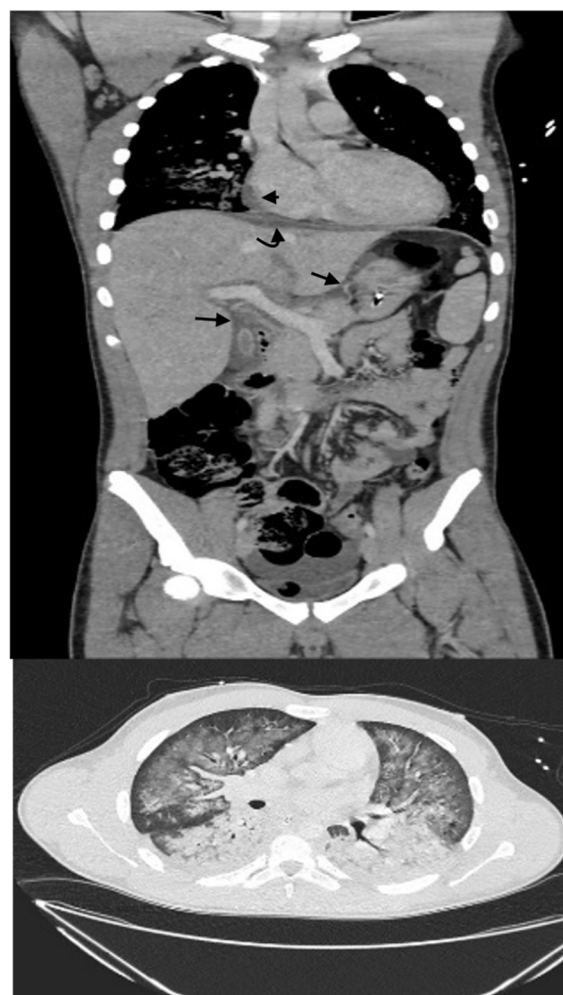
Coronal image CT scan of upper abdomen and chest shows diffuse inflammation changes and soft tissue oedema around the gallbladder, liver and within the epigastric region (Black arrows), Subphrenic oedema (Curved arrow), tiny pericardial effusion (Arrowhead). Axial image of lung bases; shows bilateral symmetrical lung changes of dense consolidation and perihilar ground-glass opacifications.
